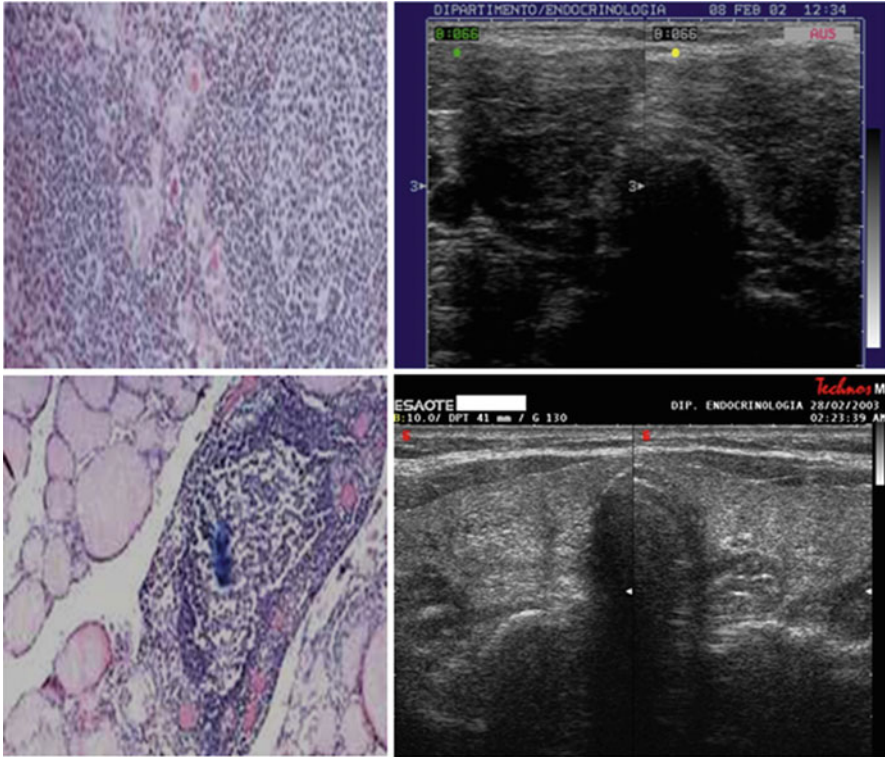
Thyroid ultrasonography and cytology in two patients with Hashimoto's thyroiditis: note hypoechogenicity and lymphocytic infiltration in patient A with diffusely enlarged thyroid gland (*top panel*: TSH 1.8 mU/L, TPOAb >1,000 kU/L, TgAb 157 kU/L) and patient B with nodular goiter (*bottom panel*: TSH 0.5 mU/L, TPOAb 1,000 kU/L, TgAb 89 kU/L) (Courtesy of Prof. Paolo Vitti, Pisa, Italy)
